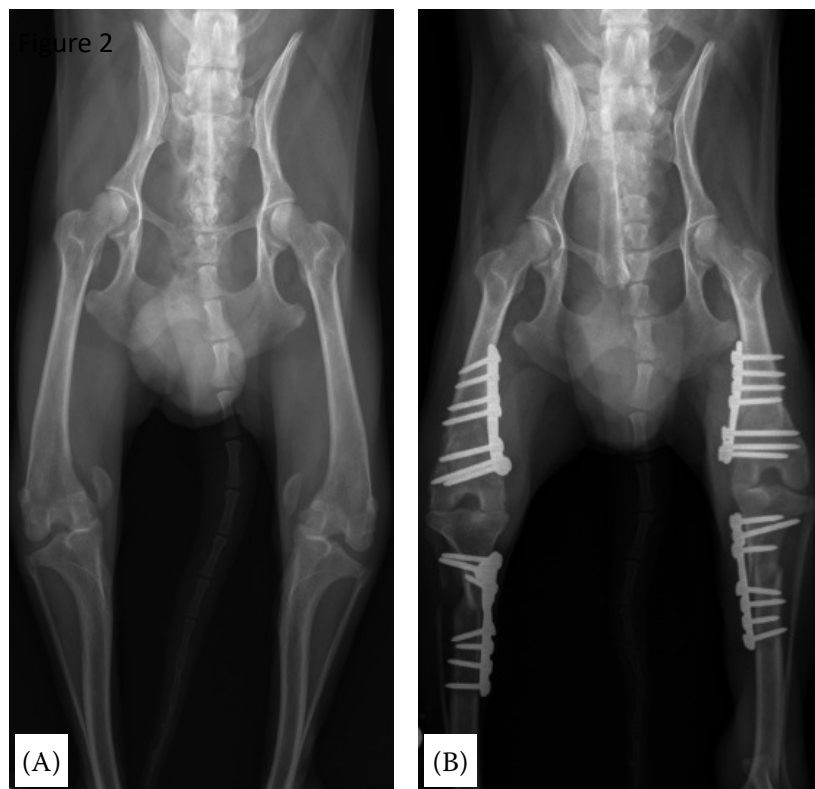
X-ray of the hip and hind limbs
